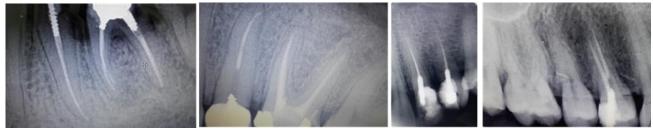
Radiographic examination showed most of the subjects restored with short posts
